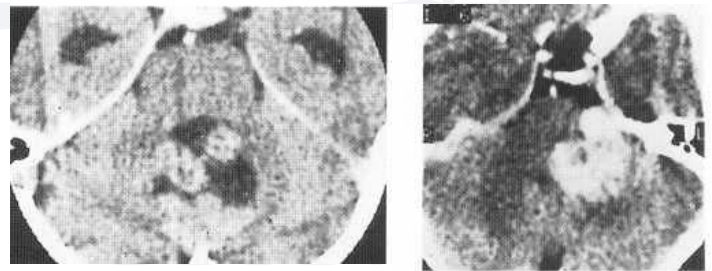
CT demonstrates moderate contrast enhancement in tumour extending from lateral invading and obstructing fourth ventricle.
